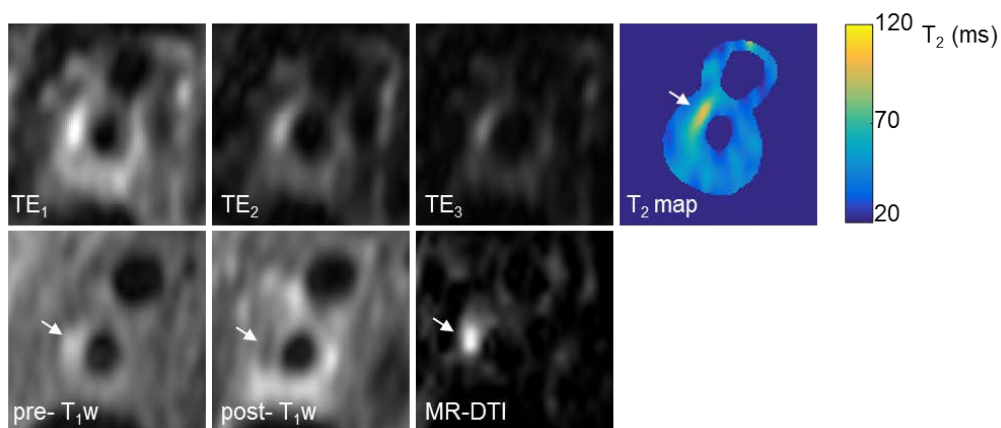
An example of recent IPH (white arrow) identified using a multi-contrast MRI protocol. Recent IPH shows higher T_2 values than the surrounding plaque region.
